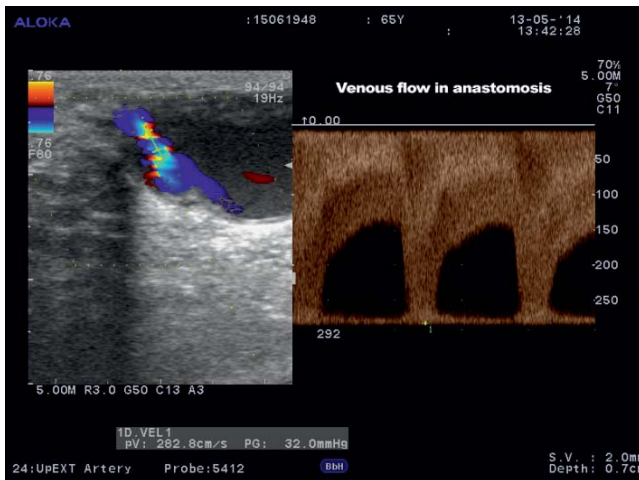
Color Doppler ultrasound of the cephalic vein at the level of anastomosis.
